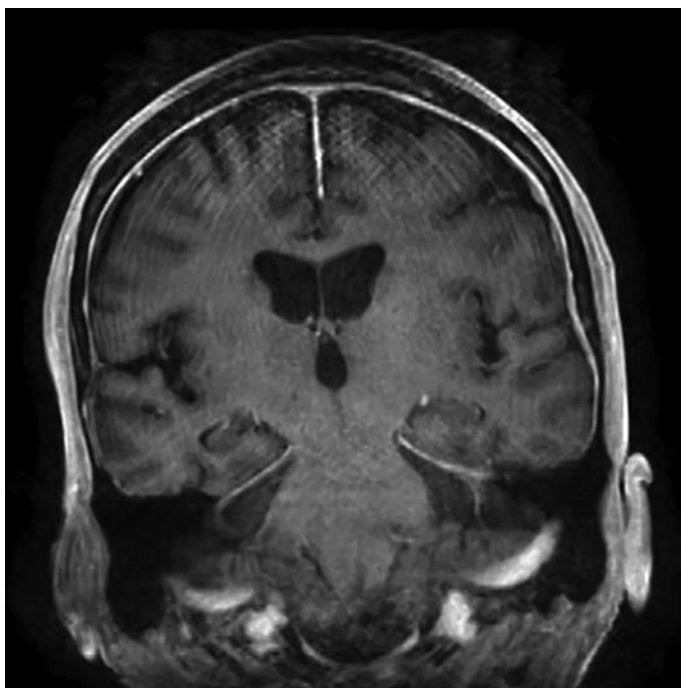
Diffuse meningeal enhancement on MRI of the brain – coronal view.
